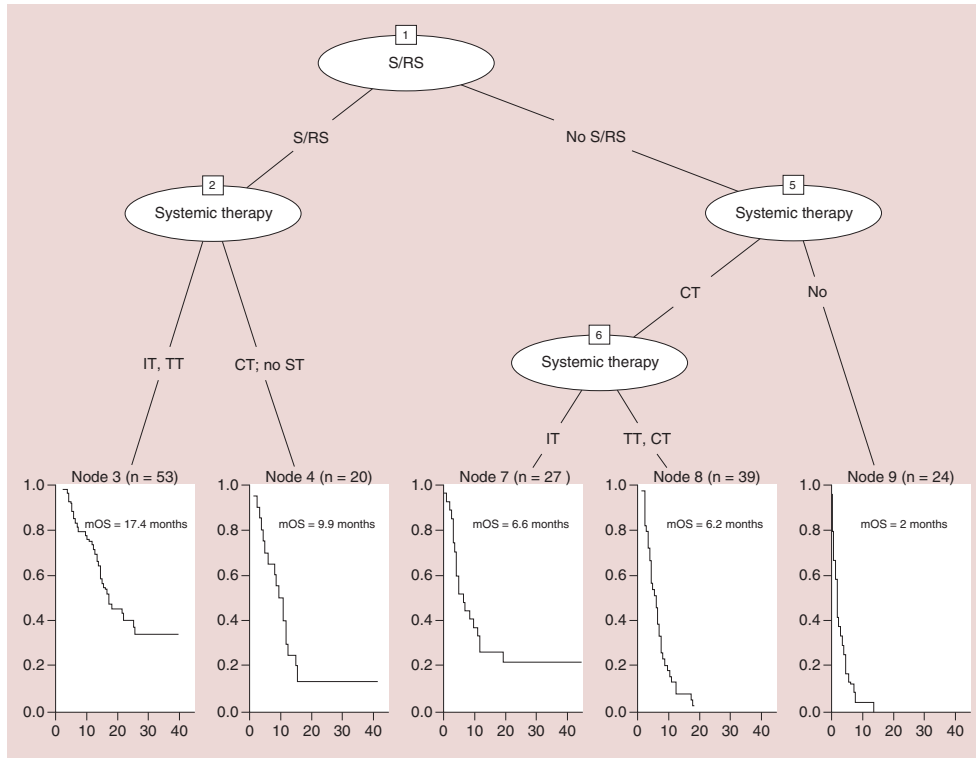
Classification and regression tree analysis. Y-axis represents the OS probability and X-axis represents time in months. In Node 5 are included the patients who received WBRT and those who did not receive any radiotherapy. CT: Chemotherapy; IT: Immunotherapy; mOS: Median overall survival; n: Number of patient; no ST: No systemic therapy; OS: Overall survival; S/RS: Surgery/radiosurgery; TT: Targeted therapy; WBRT: Whole brain irradiation.
